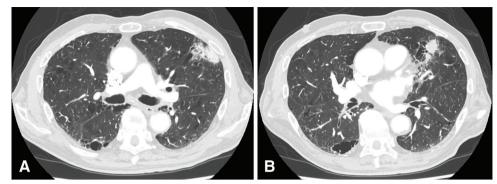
Preoperative contrast-enhanced CT images. (A) A solid tumor shadow measuring 37 mm is observed in the left upper lobe S3. (B) A solid nodular shadow measuring 29 mm is observed in the left upper lobe S4. CT: computed tomography
